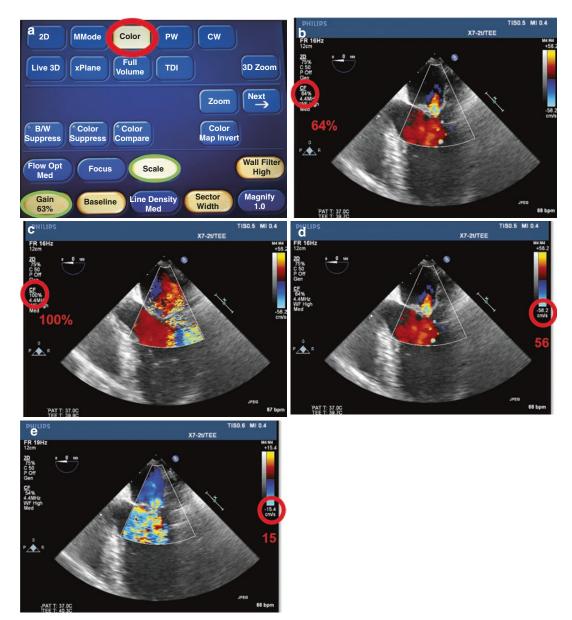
(a) The digital panel indicating the settings of gain and scale (*green circles*) that are displayed once the color flow Doppler (CFD) mode (*red circle*) is selected. Midesophageal five-chamber view of a patient with mitral regurgitation demonstrating the effects of gain and scale settings. (b) Appropriate spectral gain of 64% (*red circle*) demonstrates laminar flow exiting the left ventricular outflow tract and turbulent flow through the mitral valve. (c) Excessive gain (*red circle*) leads to a speckled appearance where there is no expected blood flow (within the myocardium) and difficulty identifying the mitral regurgitation. (d) Appropriate scale settings (*red circle*) allow the grading of mitral regurgitation. (e) Inappropriately reduced color flow scale (*red circle*) leads to aliasing at lower velocities, obscuring the mitral regurgitation and causing the inappropriate appearance of turbulent flow in the LVOT
